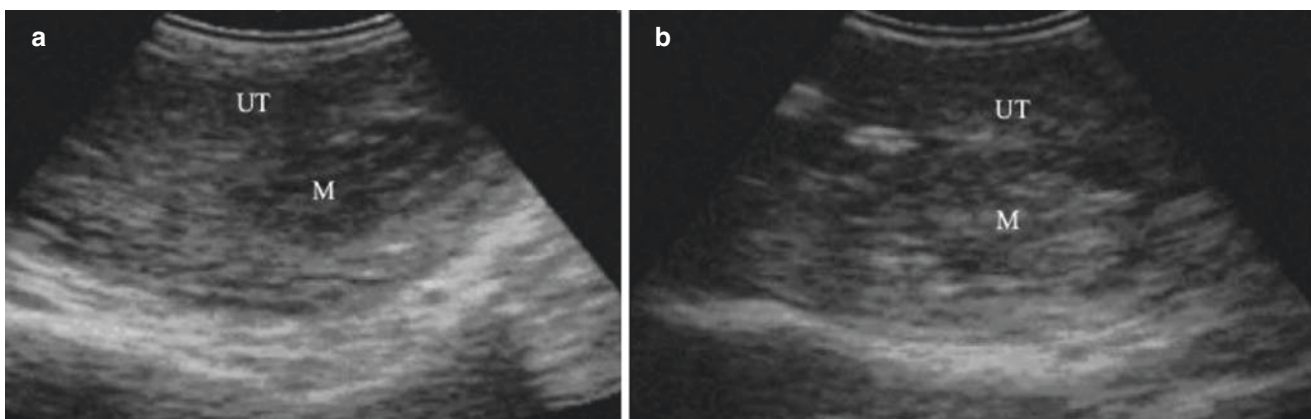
Sonohysterography of intrauterine residues (II). (a) The patient is 26 years old and developed amenorrhea after a miscarriage 2 months ago. The ultrasonography shows the posterior uterus, and the hyperechoic mass in the uterine cavity; (b) After injection of contrast
